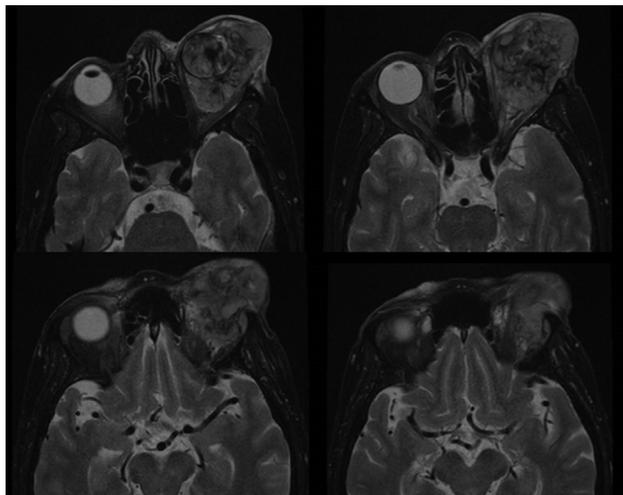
Brain magnetic resonance imaging scan showing an expansive lesion in the left eye, measuring ~ 46 mm in length in the antero-posterior direction, presenting heterogeneous signs with hypo- and hyperintense foci on T1- and T2-weighted images and postgadolinium heterogeneous enhancement. Impression of discrete postgadolinium enhancement in the canalicular portion of the left optic nerve, with atrophy of its prechiasmatic segment, is also observed.
